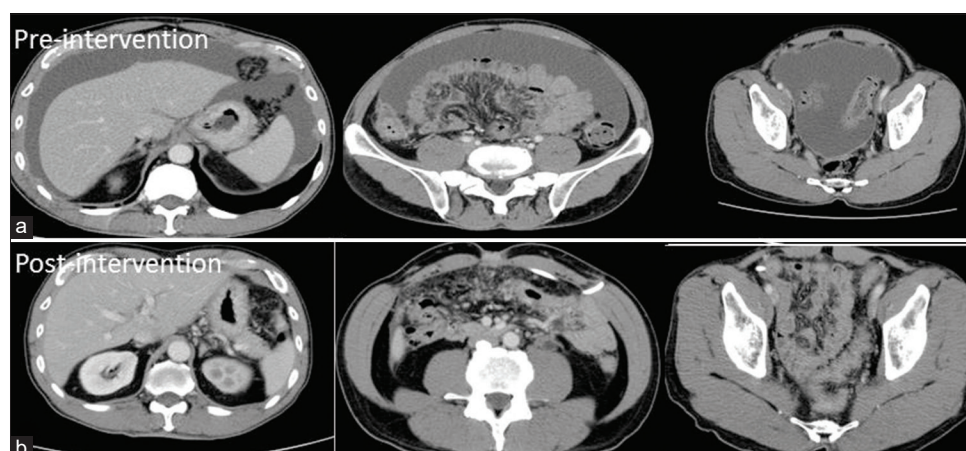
The abdominal computed tomography shows massive ascites in the peri-liver space, peritoneal cavity, and pelvic cavity at preintervention (a). After laparoscopic hyperthermic intraperitoneal chemotherapy + neoadjuvant intraperitoneal and systemic chemotherapy treatment for 3 months, the massive ascites is significantly decreased in the peri-liver space, peritoneal cavity, and pelvic cavity (b)
